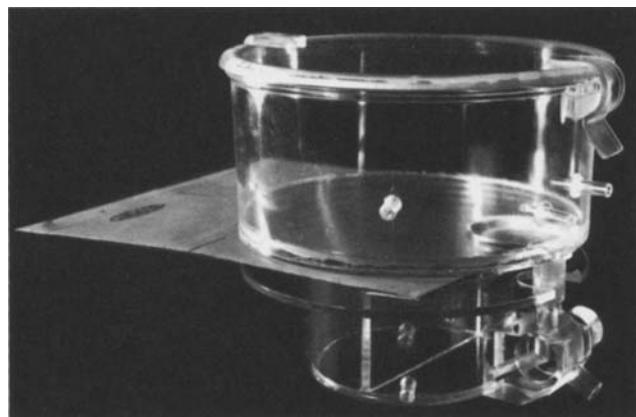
Modified organ chamber with x-ray film
